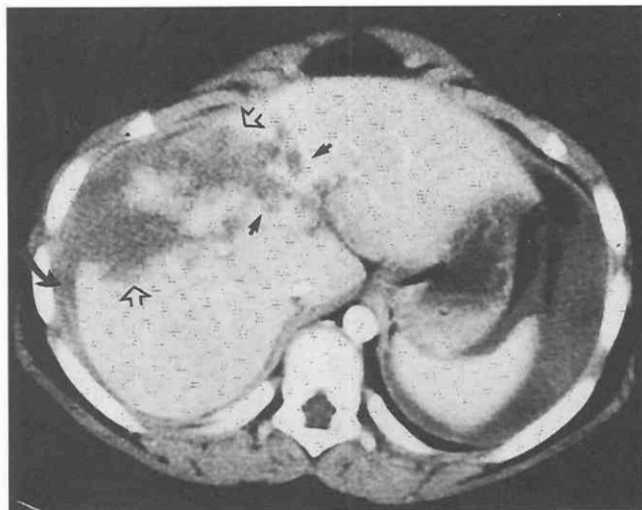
Hepatic injury. Contrast-enhanced CT image reveals a complex laceration (*arrows*) and hematoma (*open arrows*) in the liver, with an associated subcapsular hematoma (*curved arrows*). Hemoperitoneum is visible in the left upper abdomen adjacent to the spleen.
